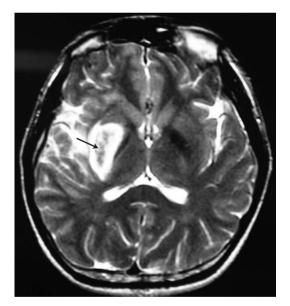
Axial T2-weighted magnetic resonance imaging of the brain shows infarction over the right basal ganglion with central hemorrhagic transformation (arrow).
